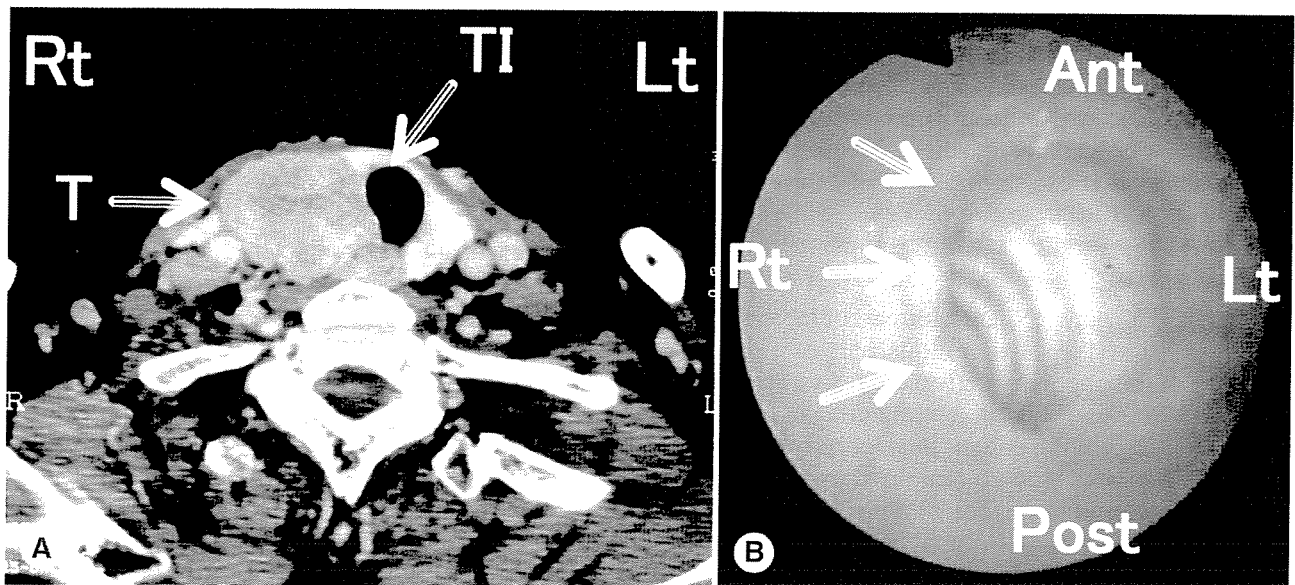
Preoperative investigation. A) Computed tomography scan. T — tumor, TI — tracheal invasion. B) Endoscopic findings. Arrows indicate tumor invasion into trachea.
